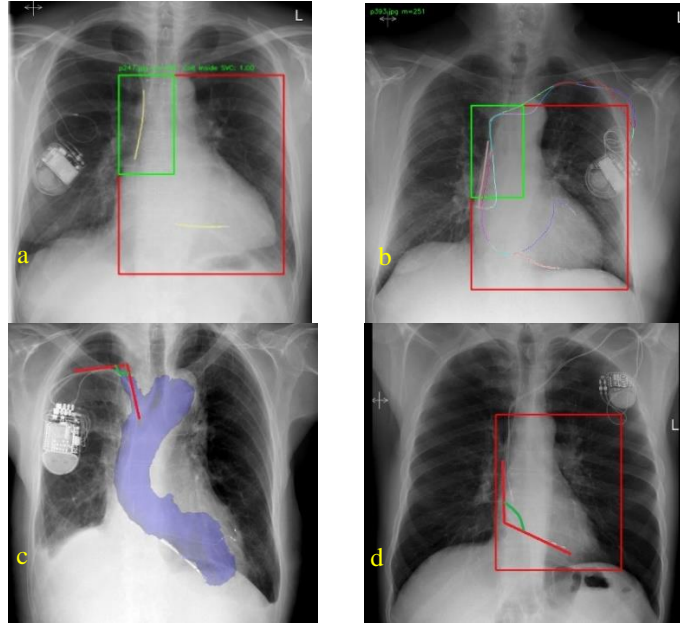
The red box is the bounding box of the outline of the heart. The green box is the approximated location of the SVC. (a) The yellow lines are the positions of coils. (b) The colorful line segmentations inside the green box indicate how many wires are inside the SVC. (c) The angle formed by two red line is the lead angulation near the entry point of the SVC. The blue shadow represents the overlay of a heart model extracted from the CT images of the same patient. (d) The angle formed by two red line is the angulation of the pacing lead in the right ventricle.
